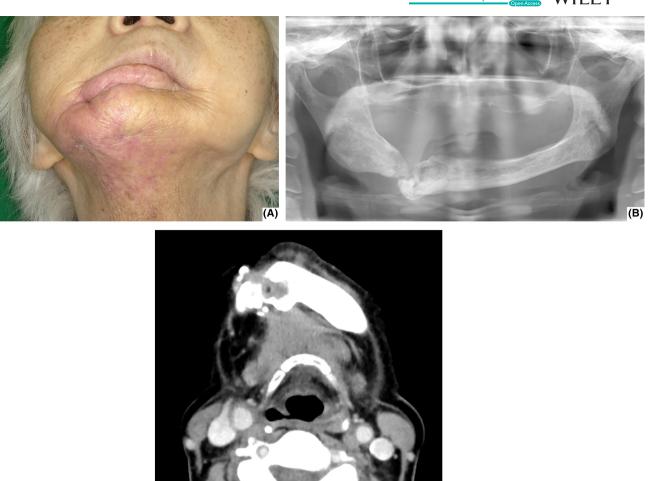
A photograph showing the patient's (A) extraoral appearance, (B) panoramic radiograph, (C) contrast-enhanced axial CT image 4 years after the initiation of nivolumab treatment.
